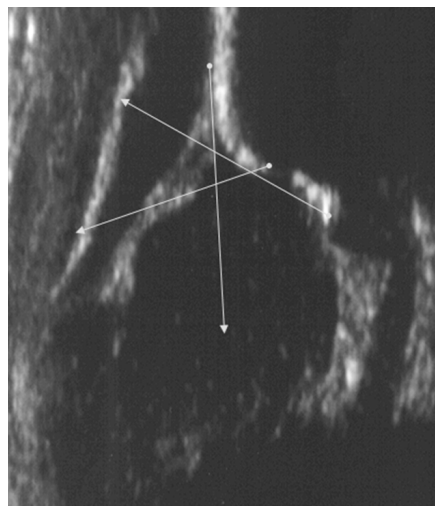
Ultrasonic finding of healthy hip
